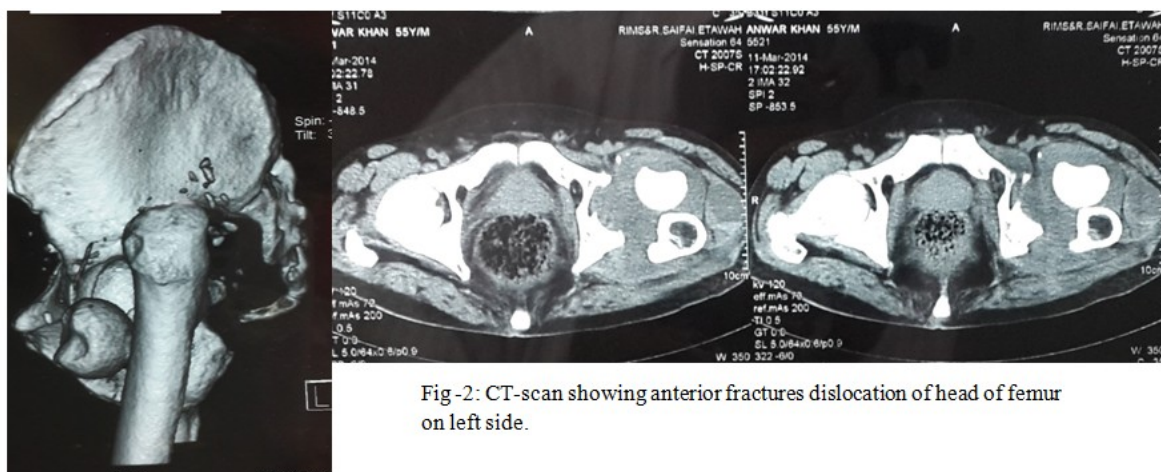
CT-scan showing anterior fractures dislocation of head of femur on left side.
